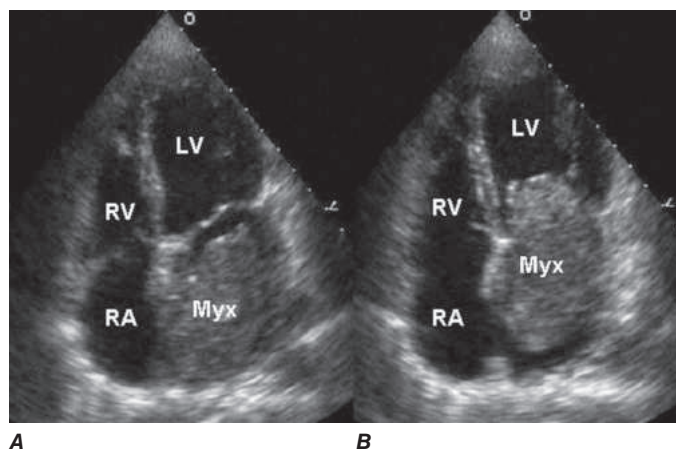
Transthoracic echocardiogram demonstrating a large atrial myxoma. The myxoma (Myx) fills the entire left atrium in systole (A) and prolapses across the mitral valve and into the left ventricle (LV) during diastole (B). RA, right atrium; RV, right ventricle. (Courtesy of Dr. Michael Tsang; with permission.)
